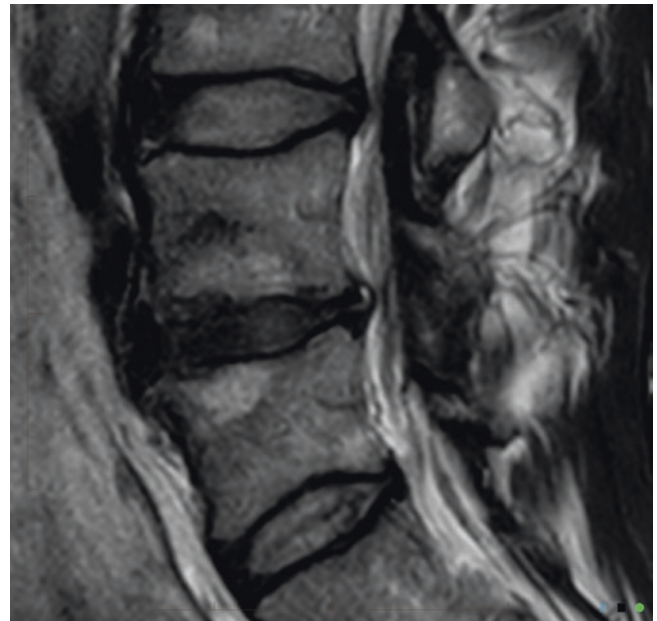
MRI of annular tear
